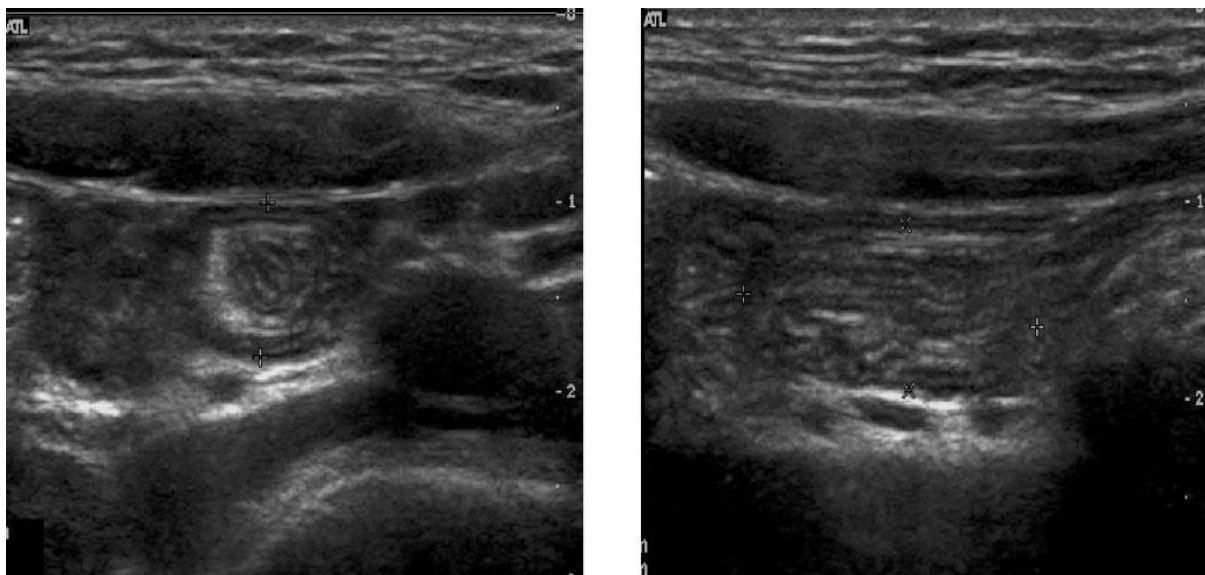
Ultrasonographic images of a 7-year-old boy with abdominal pain and typical transient small bowel intussusception. Image in transverse plain (a) shows the crescent-in-doughnut sign (cursors) and image in longitudinal plain (b) shows the sandwich sign (cursors). The diameter of the doughnut measured 0.84 cm and the thickness of the outer rim of the lesion measured 0.10 cm.
